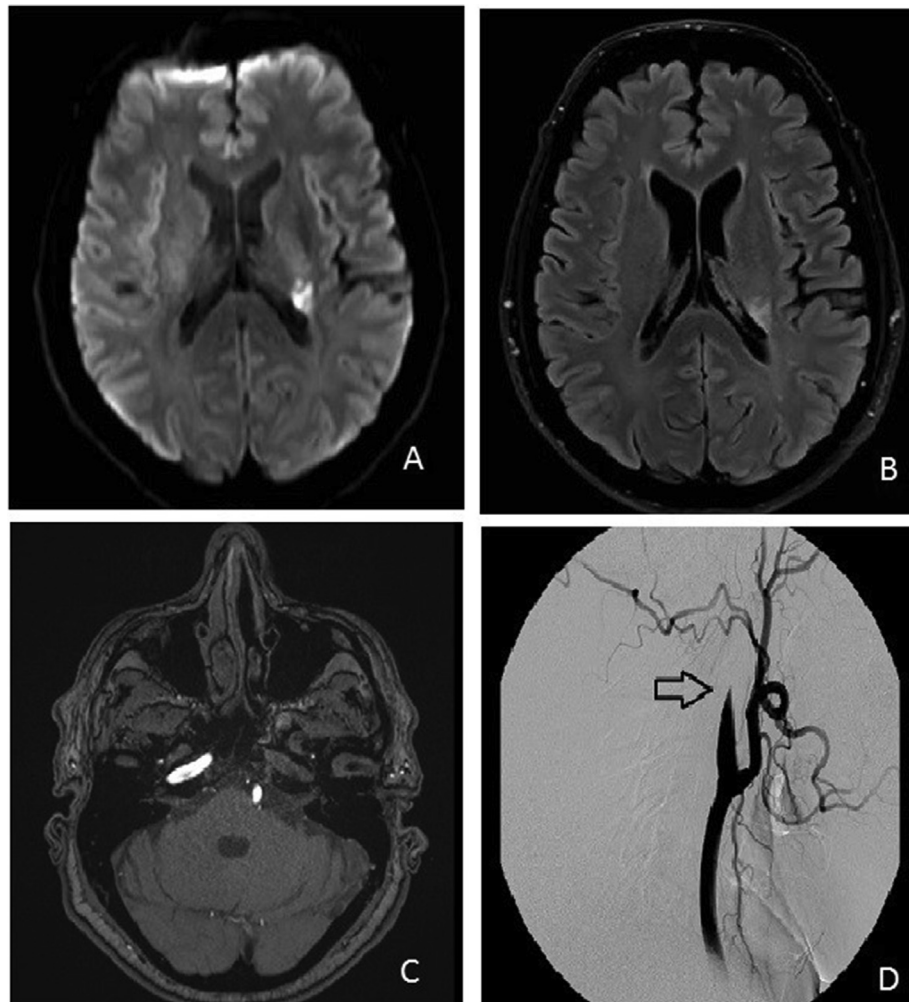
Hyper intense ischemic area of the white matter in the left periventricular region, posterior to the internal capsula is seen at diffusion (a) and fluid attenuation inversion recovery (FLAIR) (b) sequences of axial T2 MRI. (c) MRI with contrast enhancement demonstrates no blood flow in the left internal carotid. (d) Internal carotid artery thrombosis slightly above the bifurcation is seen on angiography (marked with arrow).
